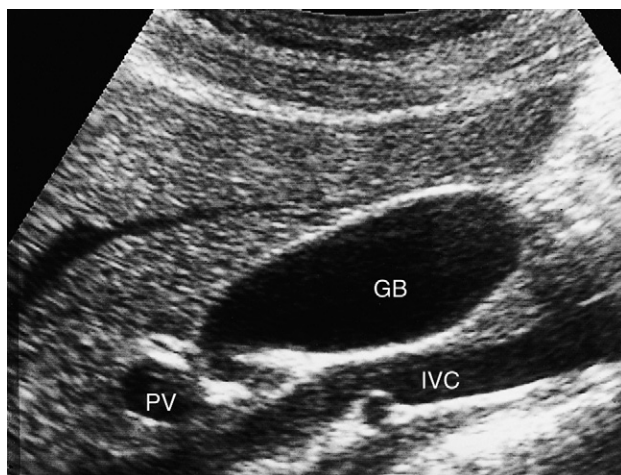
Ultrasound of normal gall bladder. Note the thin wall and absence of echoes from within the gall bladder. GB, gall bladder; IVC, inferior vena cava; PV, portal vein.
